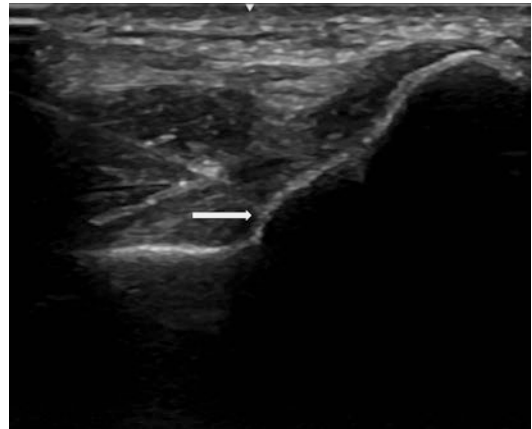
Ultrasound imaging of PRP injection of proximal UCL attachment (arrow). (© 2020 Daryl C. Osbahr, all rights reserved)
